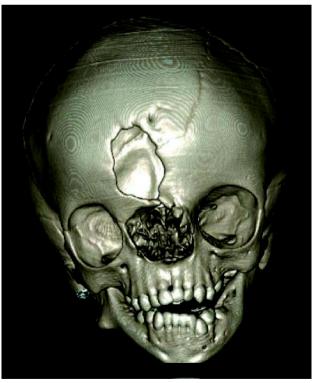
Volume rendered-3D CT of the skull showing right frontal and nasal defects
